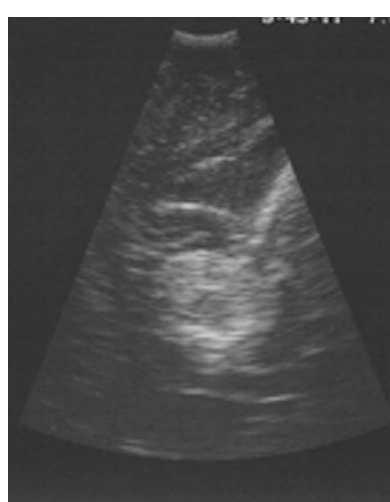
Same patient, intraoperative coronal plane ultrasound image of the lesion, through an 11-mm burr hole.
